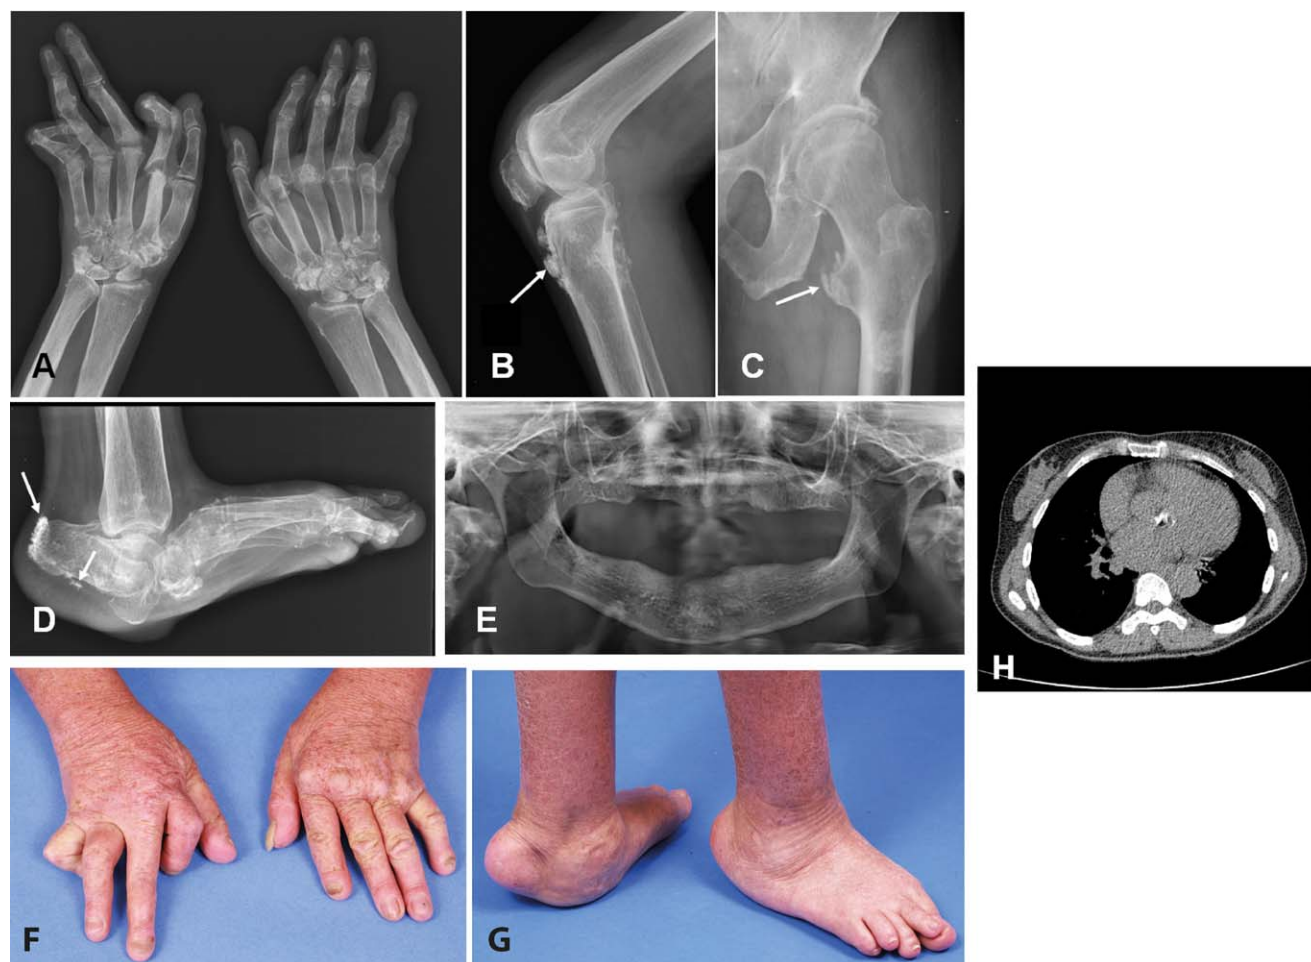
Radiologic and clinical features of patient 2 of family 1938. A–D, Radiographs of the hands (A), left knee (B), left femur and hip (C), and left foot (D) at age 45 years, demonstrating significant deformities and ectopic calcification at the sites of tendon insertions (arrows). E, Radiograph of the jaw, demonstrating a complete absence of teeth. F and G, Photographs of the hands (F) and feet (G) at age 45 years, demonstrating musculoskeletal deformities. H, Transverse computed tomography image of the chest, demonstrating dense ectopic calcification of the aortic valve. Color figure can be viewed in the online issue, which is available at <http://onlinelibrary.wiley.com/doi/10.1002/art.40179/abstract>.
